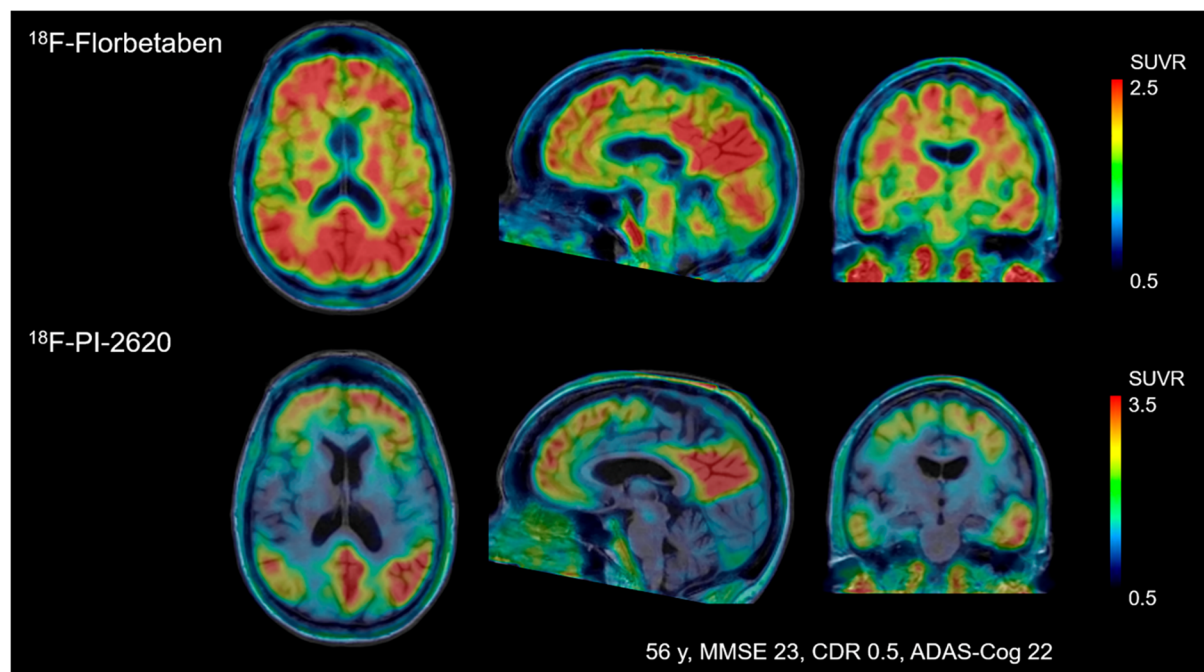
Comparison of florbetaben amyloid-PET and ¹⁸F-PI-2620 tau PET obtained in the same subject. Images were normalized to the cerebellar grey matter and co-registered to the subject's MRI.
